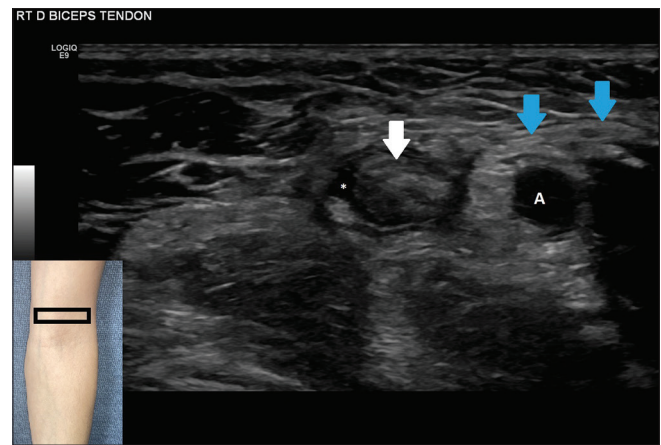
Transverse ultrasound image of an abnormally thickened ruptured distal biceps tendon (white arrow) surrounded by fluid and hematoma (asterisk), with an intact bicipital aponeurosis (blue arrow). A: Brachial artery
